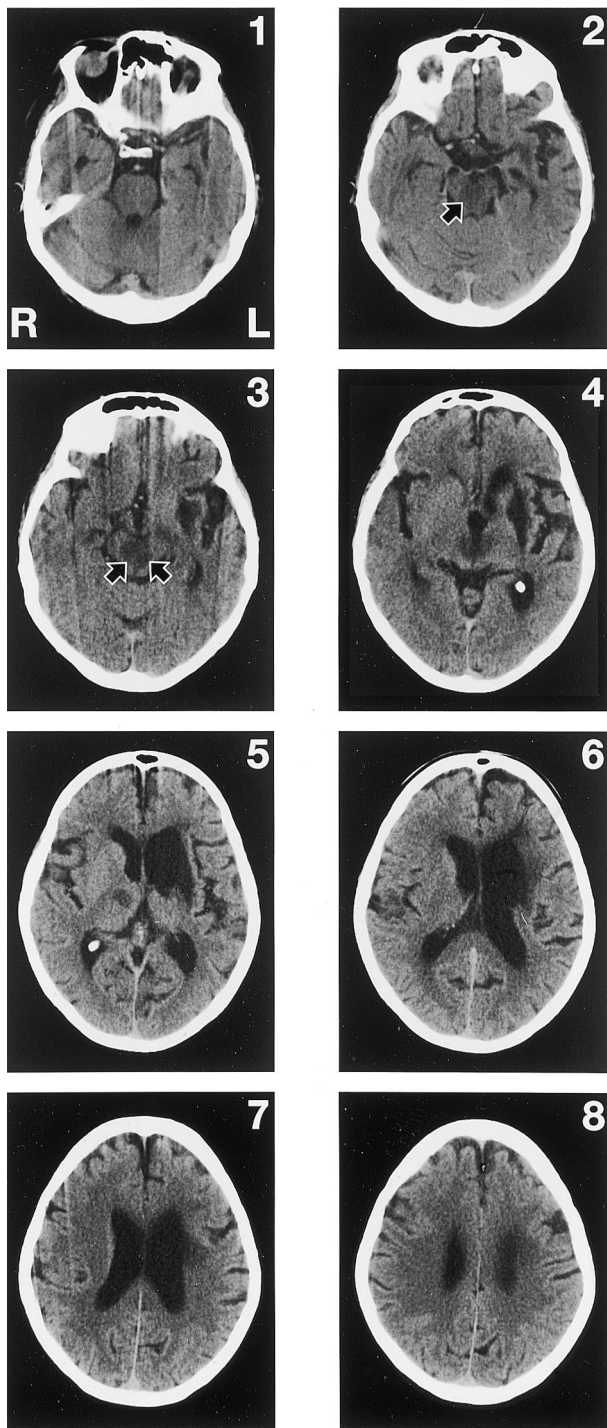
CT scan without contrast obtained 2 days after G.M. developed a complete mutism with bilateral paralysis of the third bilateral cranial nerve (ptosis, large fixed pupils and divergent strabismus) (June 1997). The number on the upper corner of each scan marks the caudal rostral progression. The CT scan shows a hypodense (ischemic) area located in the brain stem (the midbrain lesion is indicated by black arrows in the 2nd and 3rd slice); a hypodense image in the right thalamic region (5th slice), and; an old ischemic area related to the first stroke (December 1994) affecting the left lenticular nucleus, part of the head of the caudate nucleus and the left internal capsule (3rd–6th slice).
